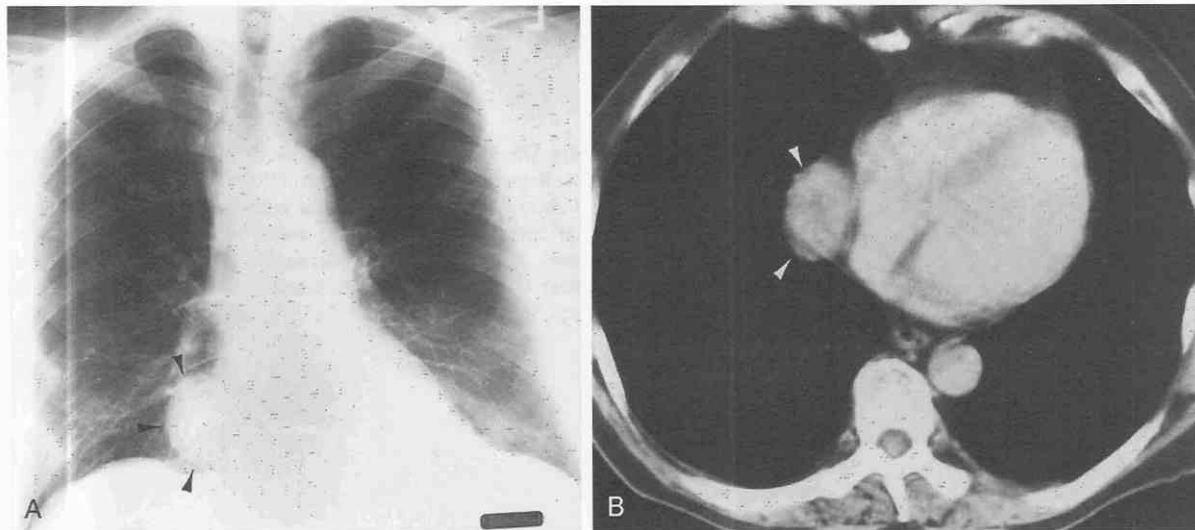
Thymoma in a patient with myasthenia gravis. *A*, Posteroanterior chest radiograph shows mass in the right cardiophrenic angle (arrowheads). *B*, Contrast-enhanced CT confirms well-circumscribed heterogeneous cardiophrenic-angle mass (arrowheads). Resection revealed the thymoma.
